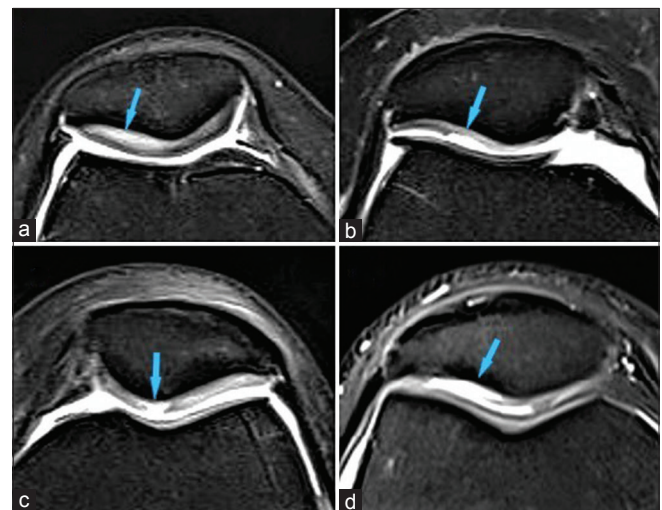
Axial proton density weighted, fat-suppressed magnetic resonance images showing patellar cartilage lesions according to modified Noyes system. (a) Grade 1, (b) Grade 2, (c) Grade 3, and (d) Grade 4, cartilage changes are seen
